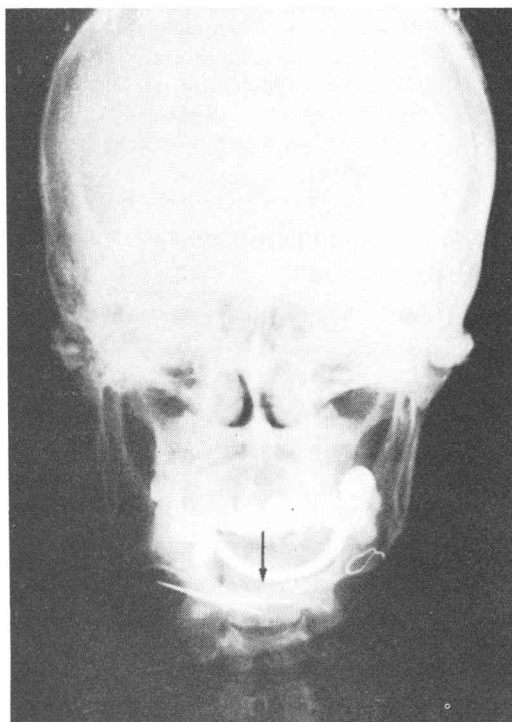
Postanterior radiograph the 4th year after inferior border regrafting (arrow) and two Kirschner wires fixation of Case 4. The junctional portion of bone regrafting is obscure.
